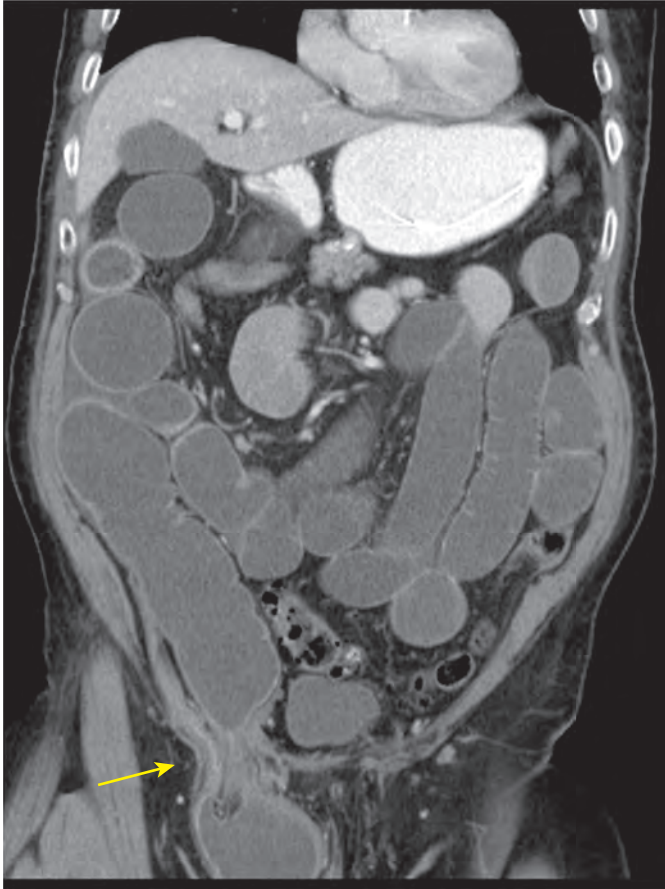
CT scan demonstrating inguinal hernia. Coronal reformatted image shows a right inguinal hernia (arrow) causing distal ileal obstruction.
